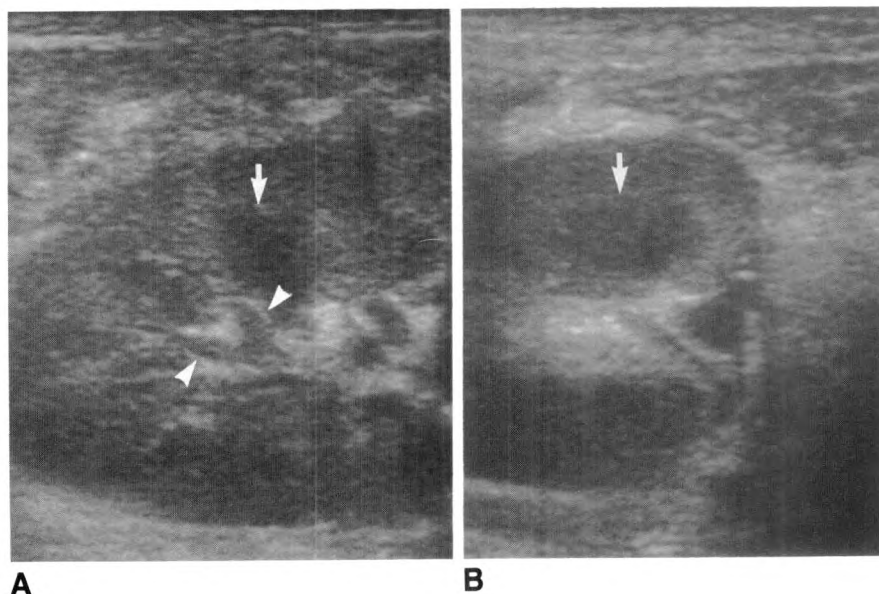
Longitudinal (A) and transverse (B) sonograms showing a renal allograft erroneously diagnosed as undergoing acute rejection. Mild swelling was observed. Infundibular walls appear thickened (arrowheads). Medullary pyramids (arrows) appear large and conspicuous.
